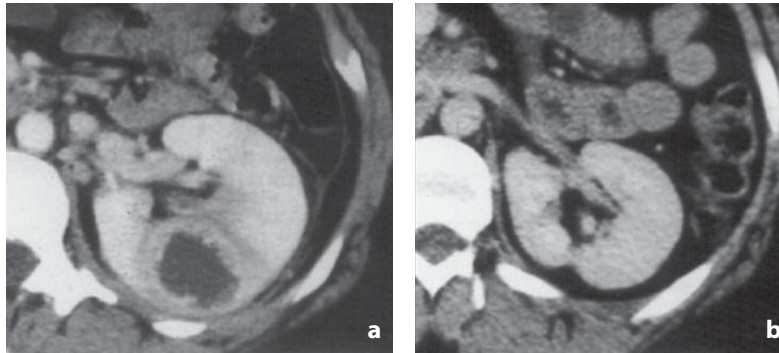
Contrast-enhanced CT. a The image shows a rounded lesion, water-like attenuation and a thick irregular wall attributable to an abscess. b After medical therapy complete resolution is achieved with residual parenchymal scarring
